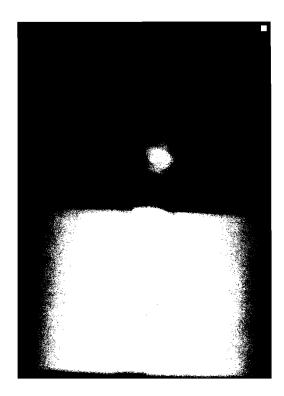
Abutment fracture was observed on the radiograph (Blue Sky Bio #9).
